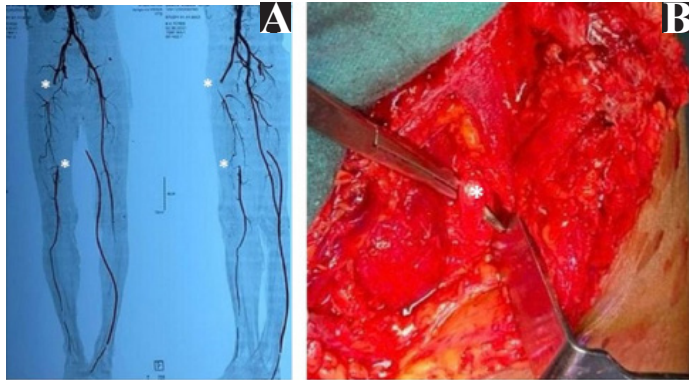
A. CT angiography of the left lower limb showing segment of the superficial femoral artery with lack of contrast opacification; B. Intraoperative image showing contused superficial femoral artery exposed during surgical exploration
